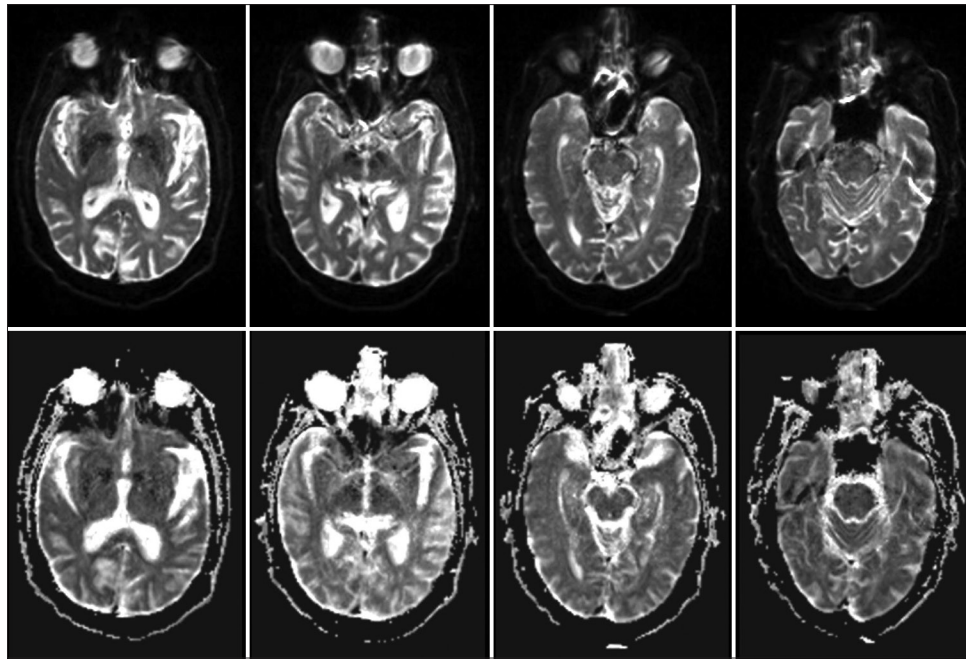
Axial MRI showing unremarkable DWI and ADC images
